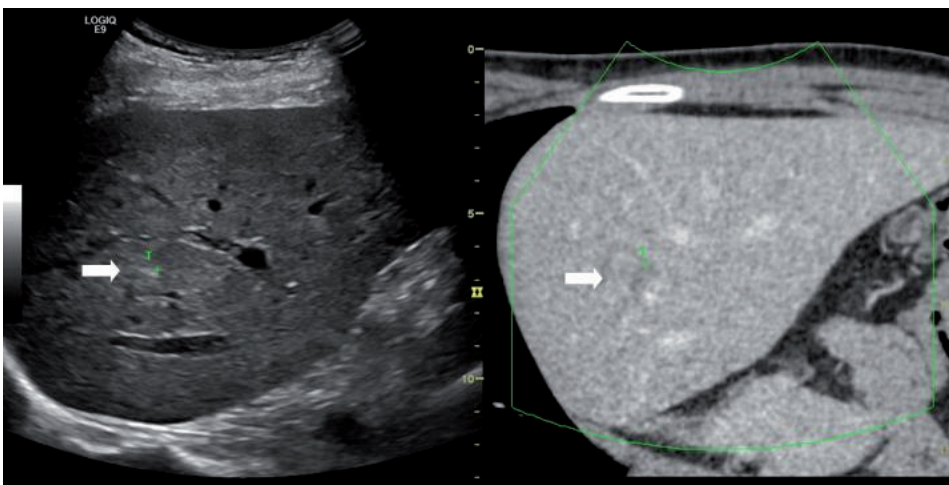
The image fusion mode allows the data from the ultrasound scan currently in progress to be shown on the same screen as the reconstructed CT scan images in the plane chosen by the user performing the exam. The segment VII lesion is seen much more clearly in the CT examination.
